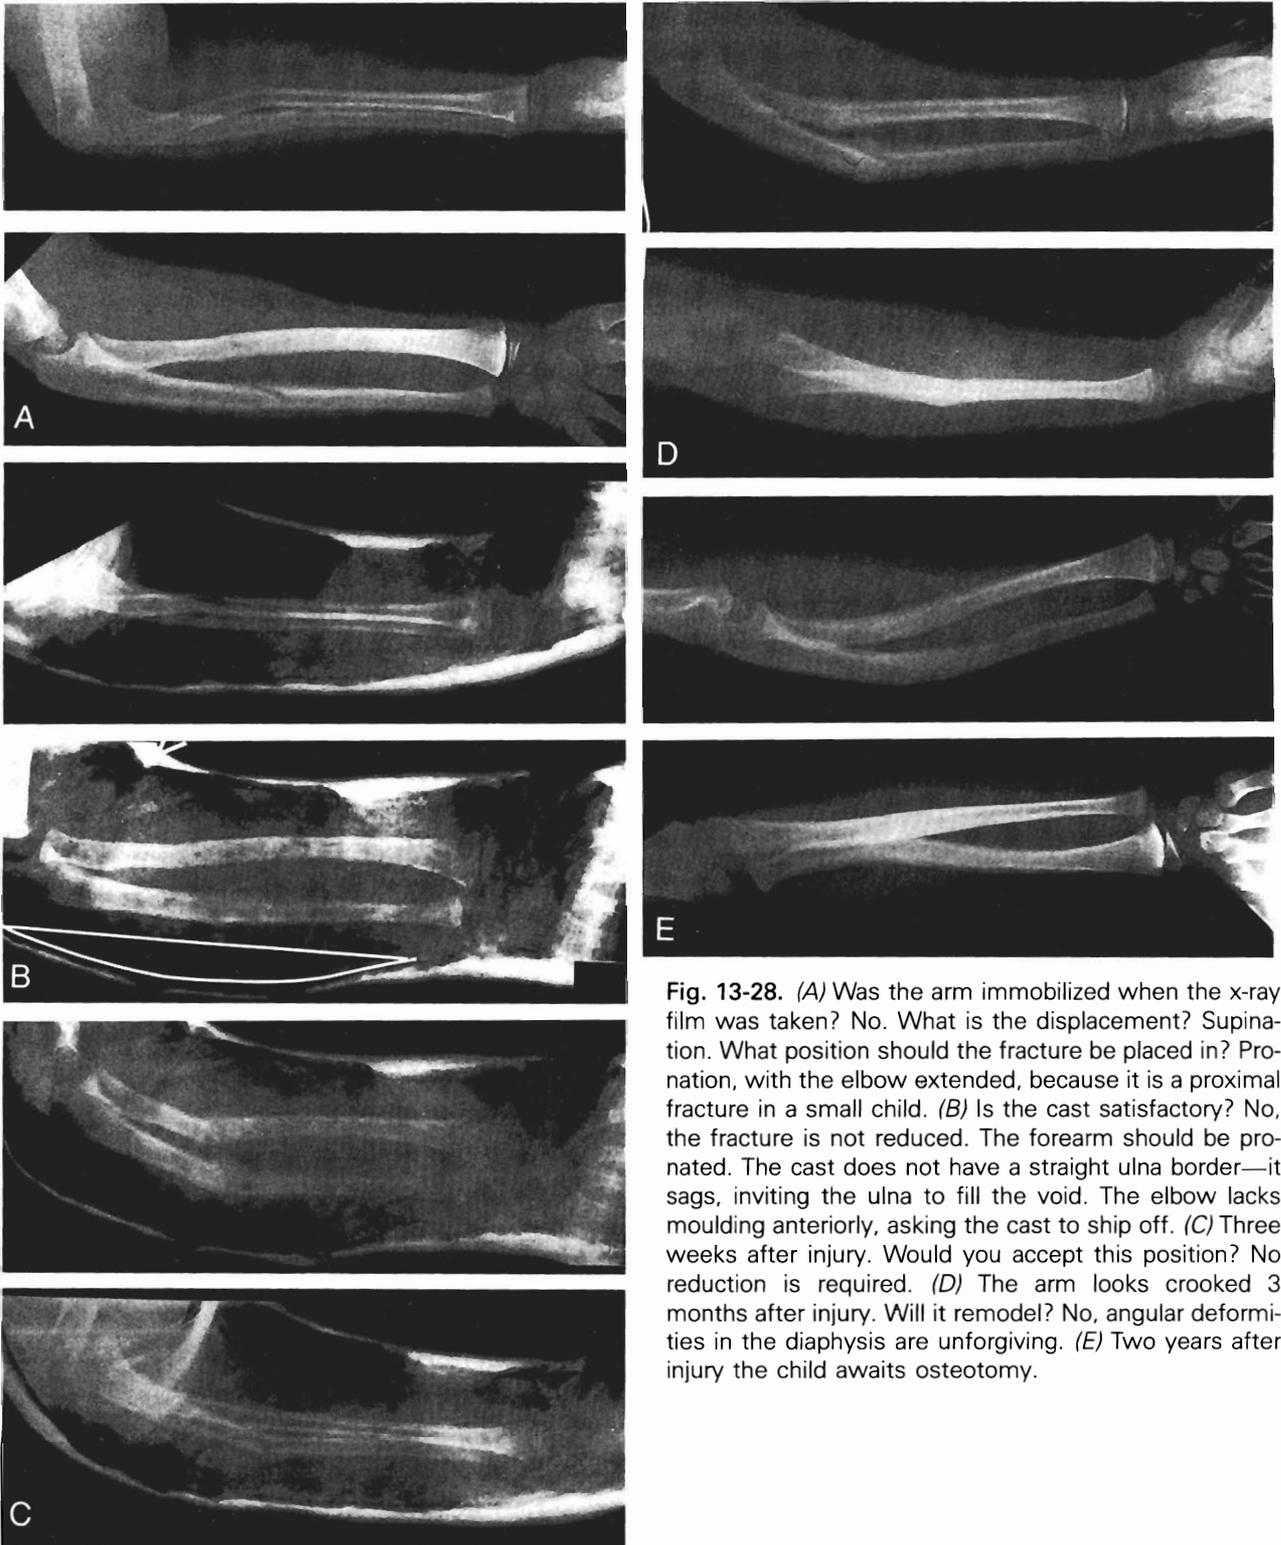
(A) Was the arm immobilized when the x-ray film was taken? No. What is the displacement? Supination. What position should the fracture be placed in? Pronation, with the elbow extended, because it is a proximal fracture in a small child. (B) Is the cast satisfactory? No, the fracture is not reduced. The forearm should be pronated. The cast does not have a straight ulna border—it sags, inviting the ulna to fill the void. The elbow lacks moulding anteriorly, asking the cast to ship off. (C) Three weeks after injury. Would you accept this position? No reduction is required. (D) The arm looks crooked 3 months after injury. Will it remodel? No, angular deformities in the diaphysis are unforgiving. (E) Two years after injury the child awaits osteotomy.
